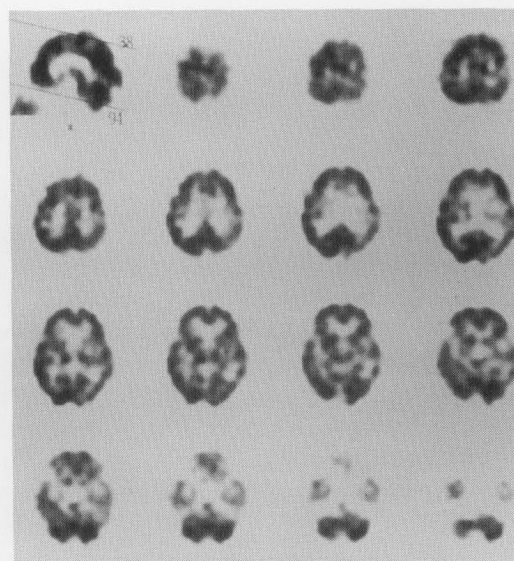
I-123 IMP SPECT images after surgery. Compared to IMP images before surgery, hypoperfused area in left MCA territory was significantly improved and CCD had disappeared.
